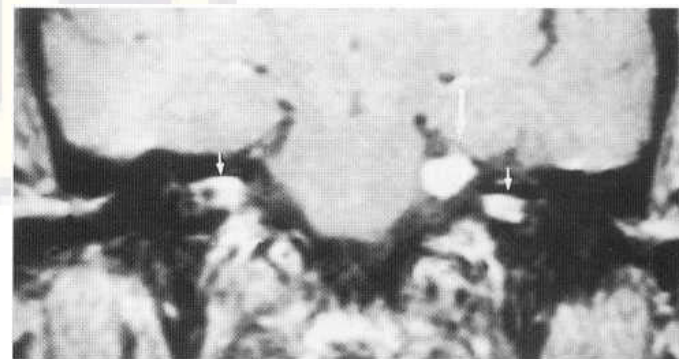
Coronal Gd-MRI showing bilateral intrameatal acoustic neuromas (small arrows) and a trigeminal neuroma (large arrow) in a patient with neurofibromatosis (NF2).
